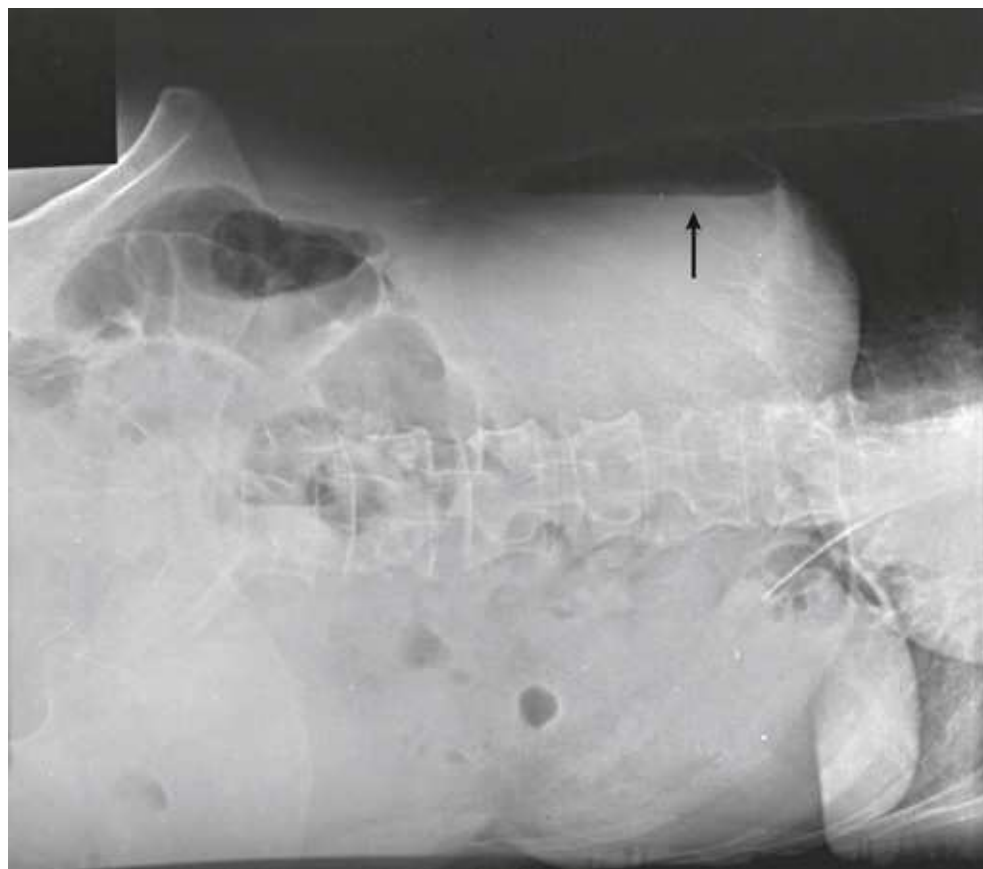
Mobile AP of the abdomen: left lateral decubitus position. Free intraperitoneal air is seen on the upper or right side of the abdomen (*arrow*). The radiograph is slightly underexposed to show free air more easily.
